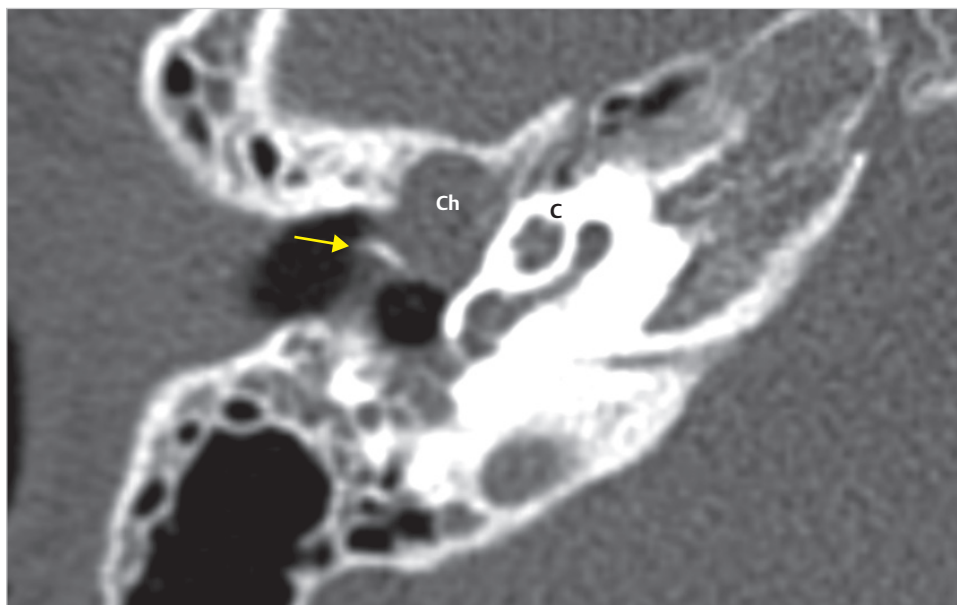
The axial CT demonstrates a round-shaped soft tissue anteriorly to the handle of the malleus (*arrow*) eroding the superior wall of the eustachian tube. The posterior half of the tympanic cavity is free of disease. C, cochlea; Ch, cholesteatoma.
